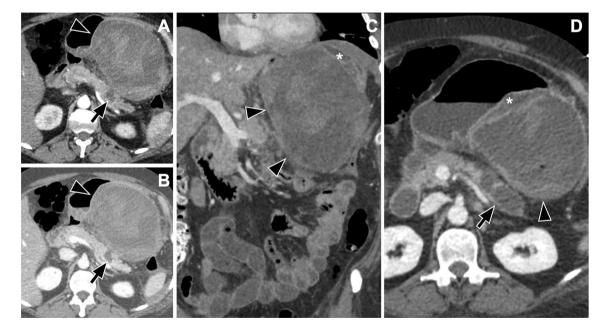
A 51-year-old male patient with a history of abdominal pain (duration: 4–6 week) presented with acute pancreatitis. On axial (a and b) and coronal (c) contrast-enhanced CT scan a focal non-enhancing area in the pancreatic tail (arrow) is present with an encapsulated inhomogeneous fluid collection (arrow head: 23.4×12.6 mm) adjacent to it, consistent with necrotic pancreatitis with associated
